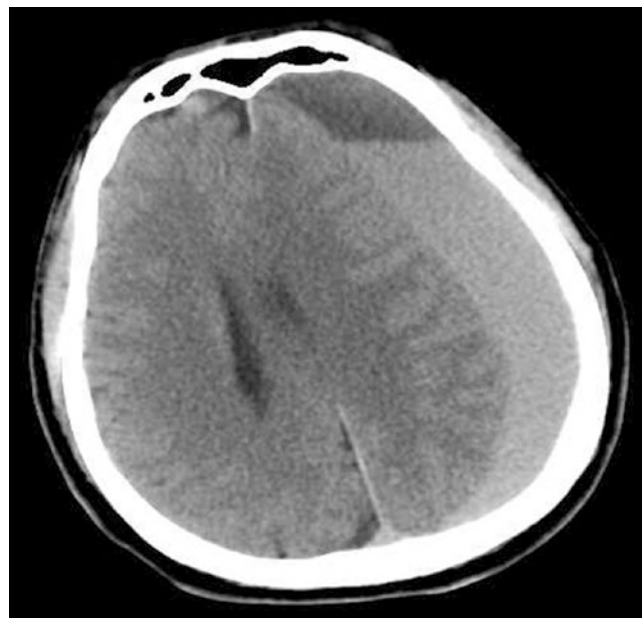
CT scan showing subdural haematoma. (Reproduced with permission of Dr. Andrew-Owen Jones)
